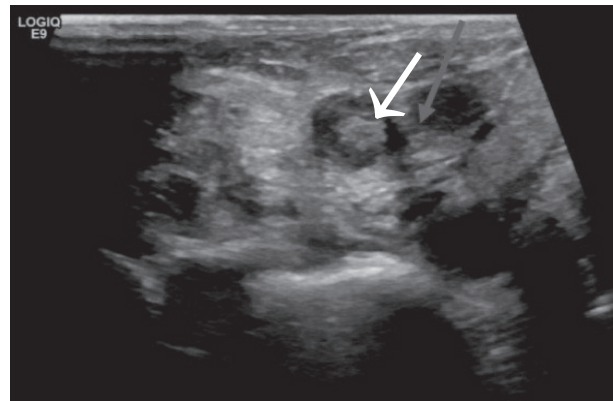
Ultrasound Neck Showing an Echogenic Thrombus in the Lower Segment of Right Internal Jugular Vein (Arrow)
